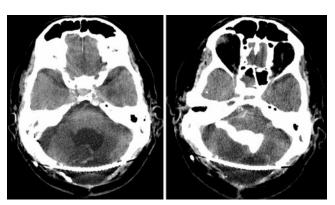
Case 4. *Left:* A CT scan obtained in a patient with negative-pressure hydrocephalus and presumed communicating hydrocephalus. The size of the patient's ventricles changed, depending on the level of drainage of the EVD. *Right:* A CT scan obtained after the injection of Iohexol dye showing complete obstruction of CSF outflow from the fourth ventricle into the CSAS.
